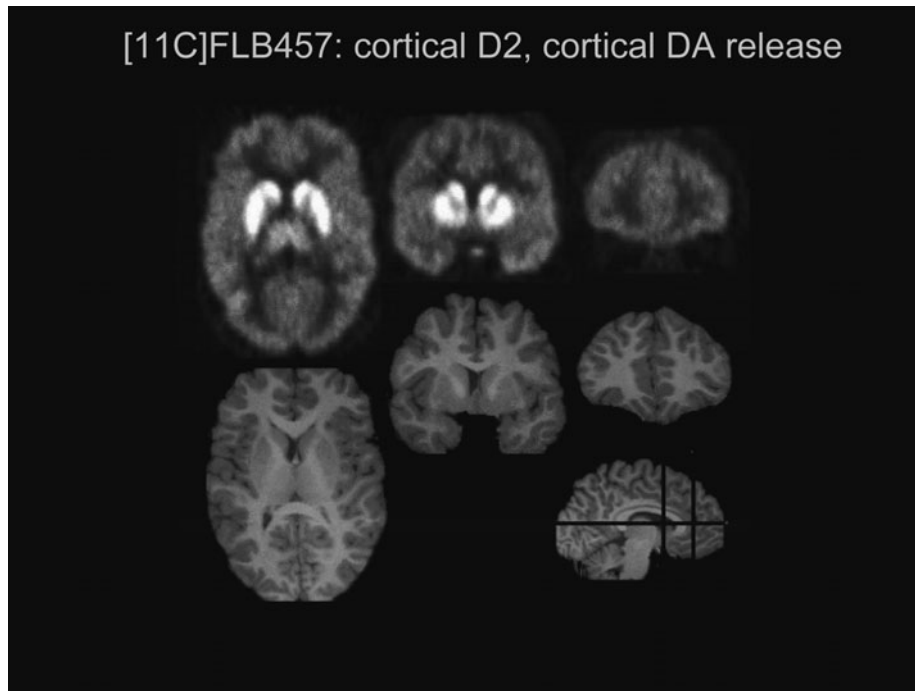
Imaging cortical D2 receptors with  $[^{11}\text{C}]$  FLB 457 scan: here, a scan under baseline conditions with coregistered (SPGR, Spoiled gradient recalled; MRI, Magnetic resonance imaging). Shown are a transverse slice (left) at the level of the striatum and thalamus and coronal slices at the level of the striatum (center) and frontal cortex (right). The sagittal slice (bottom right, not to scale) has lines through the three slice levels. Note the pituitary gland in the center coronal slice. (See Color Plate 10.1.1.)
